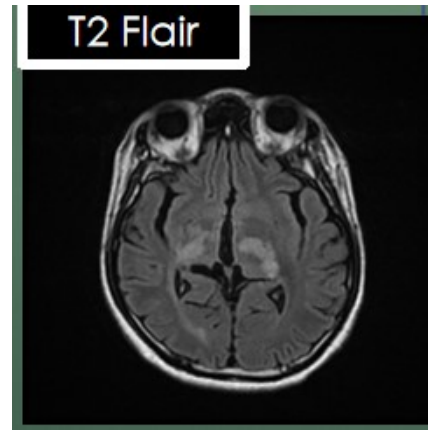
MRI Head Axial contrast
